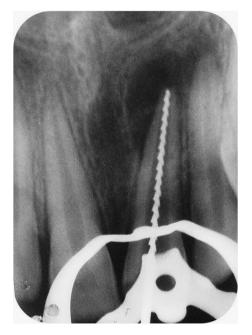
Working length radiograph - tooth 21.
